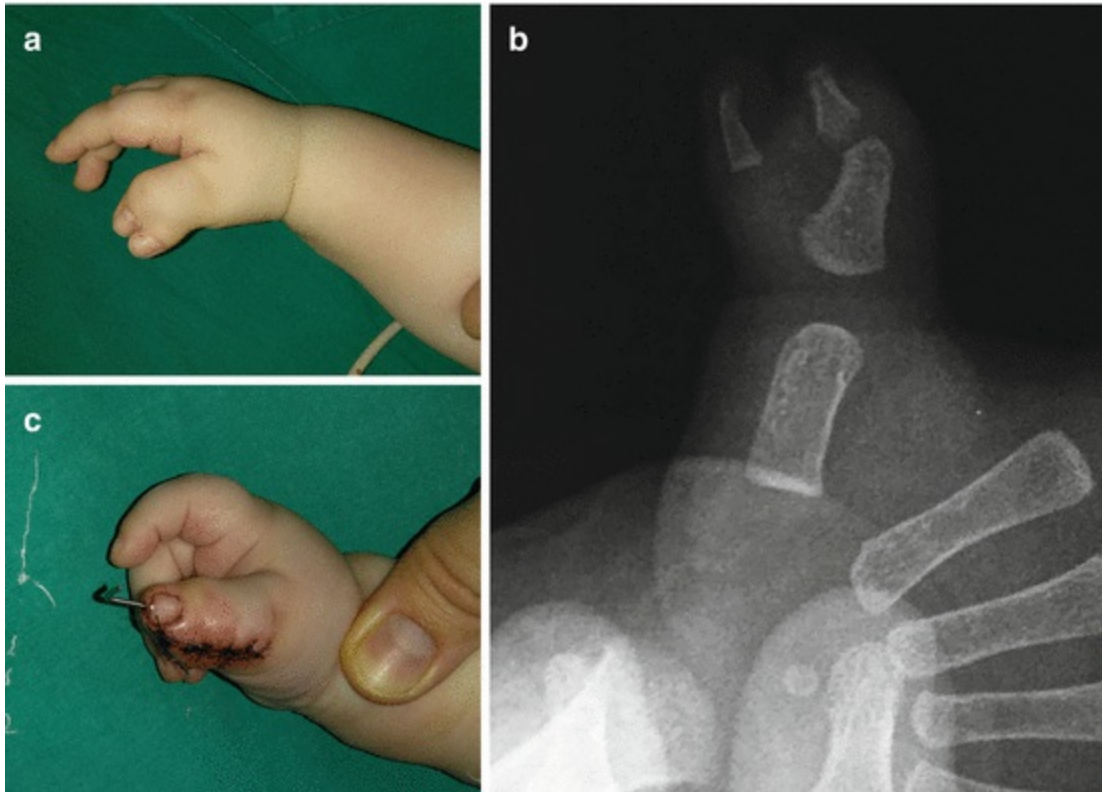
Reconstruction of thumb duplication by excision of the radial part of the thumb: (a) preoperative view; (b) radiography of the thumb; (c) postoperative view
